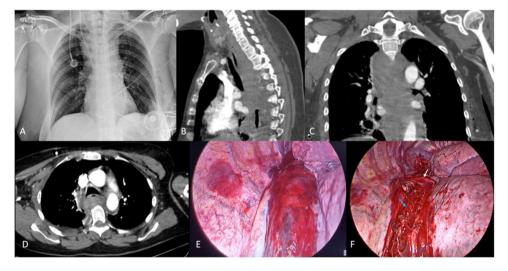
(A) Mediastinal widening visible on chest X-ray; (B) mediastinal hematoma (MH) visible in the sagittal section of the CT; (C) MH visible in the coronal section of the CT; (D) MH visible in the axial section of the CT at the level of T6; (E) video-thoracoscopic view of the MH; (F) video-thoracoscopic view after drainage of the MH. White arrow: azygos vein. Blue arrow: esophagus.
